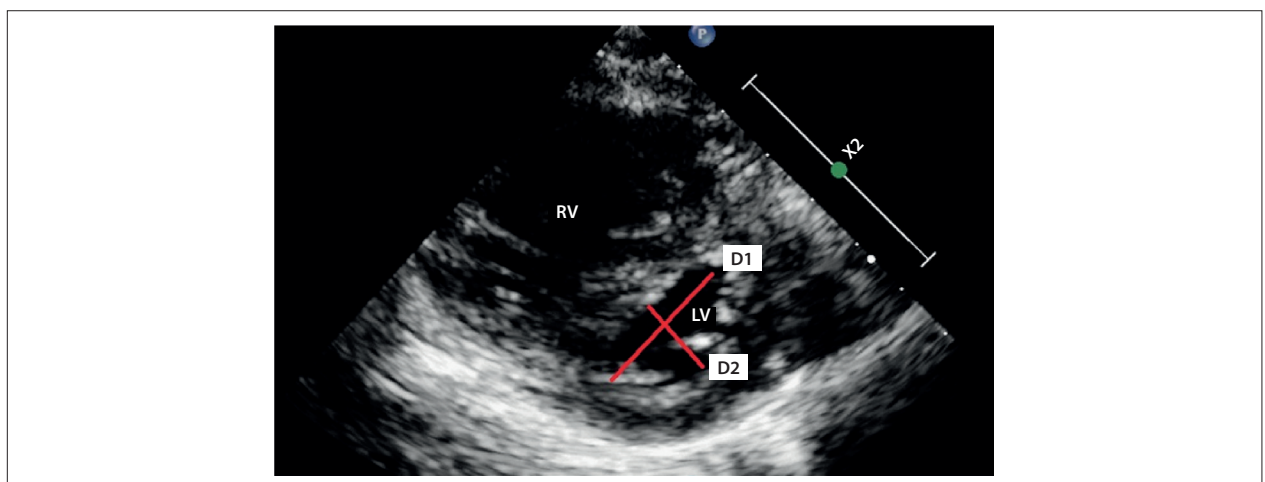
End-systolic parasternal short axis view. The eccentricity index is the D1/D2 ratio.
